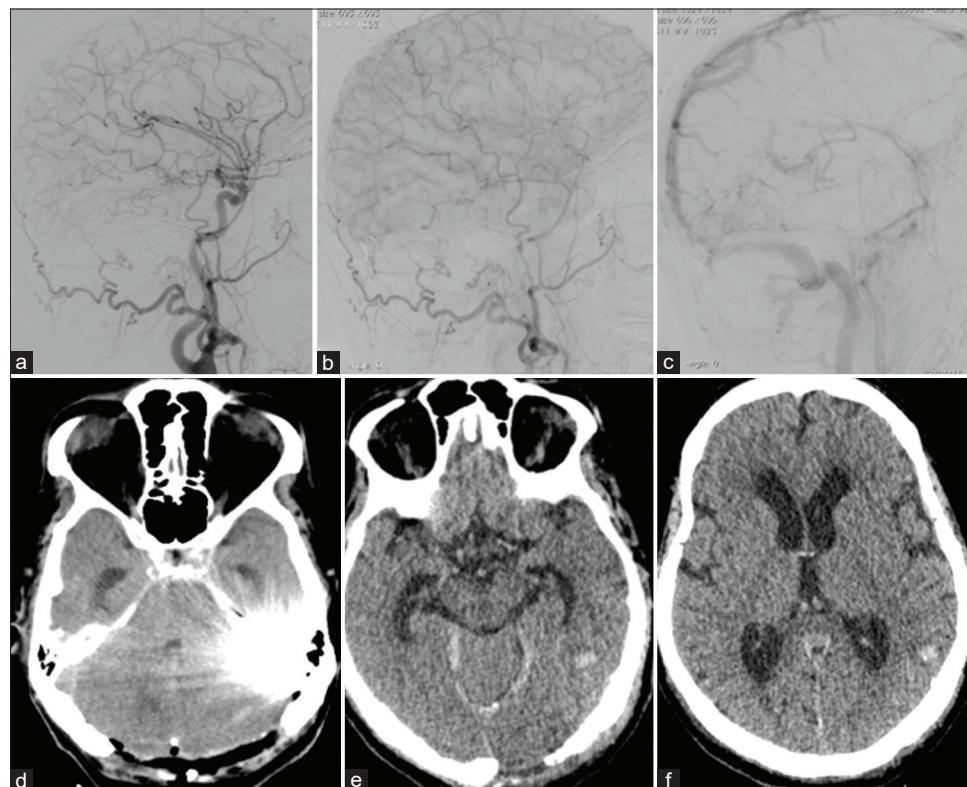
(a-c) Postoperative digital subtraction angiography of left internal carotid artery injection demonstrating no residual dural arteriovenous fistula. (d-f) Axial sections of computed tomography of brain demonstrating occipital craniotomy postoperative changes with Onyx cast artifacts and decreased lateral ventricular dilatation
